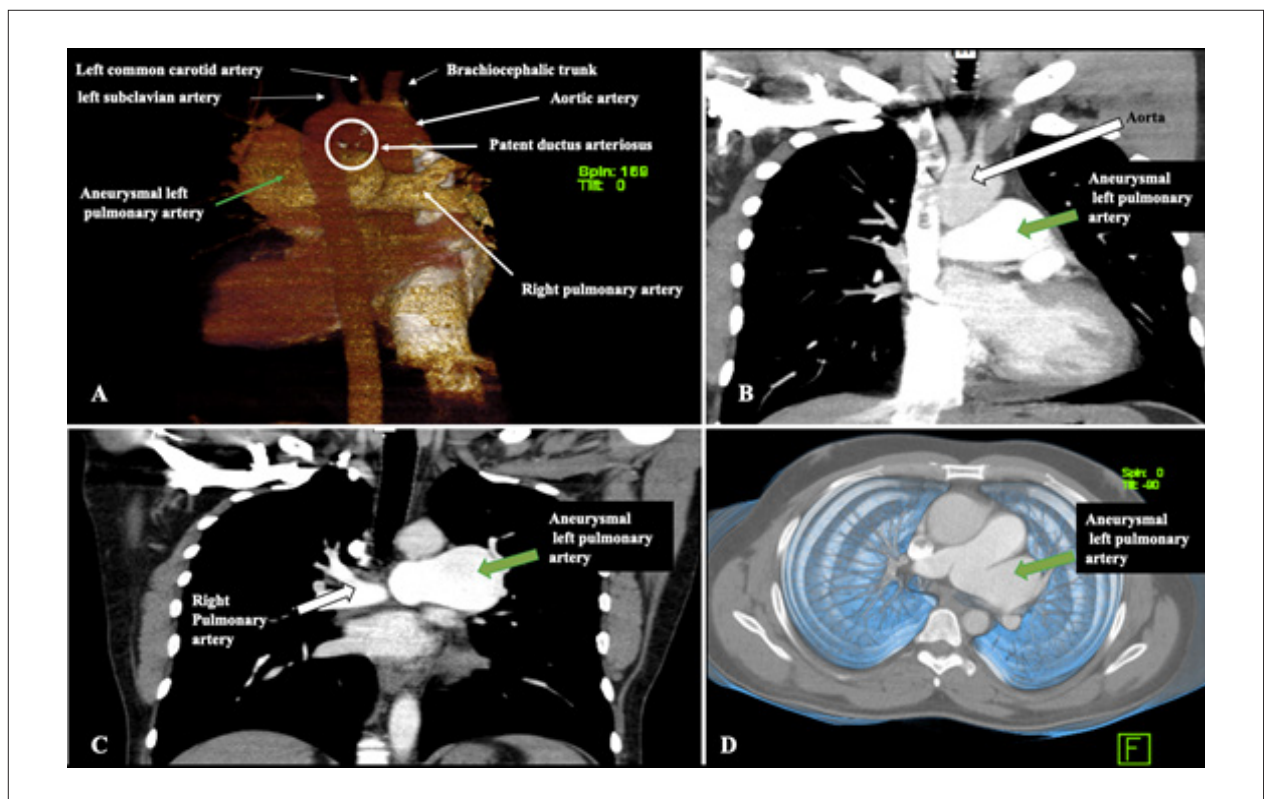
Chest computed tomography angiography, A) PDA (White circle); B-D) Aneurysmal left pulmonary artery (green arrow)
